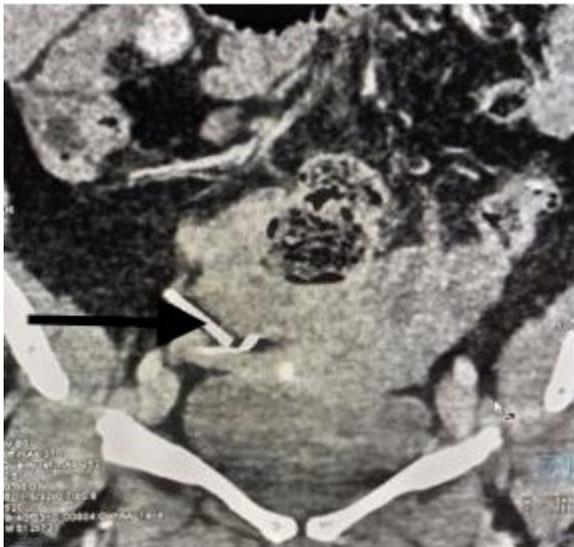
Computed Tomography (CT) of the pelvis. The arrow shows an inverted IUD in a position contrary to the expected normal upright "T." The IUD is partly embedded into the parametrium.
